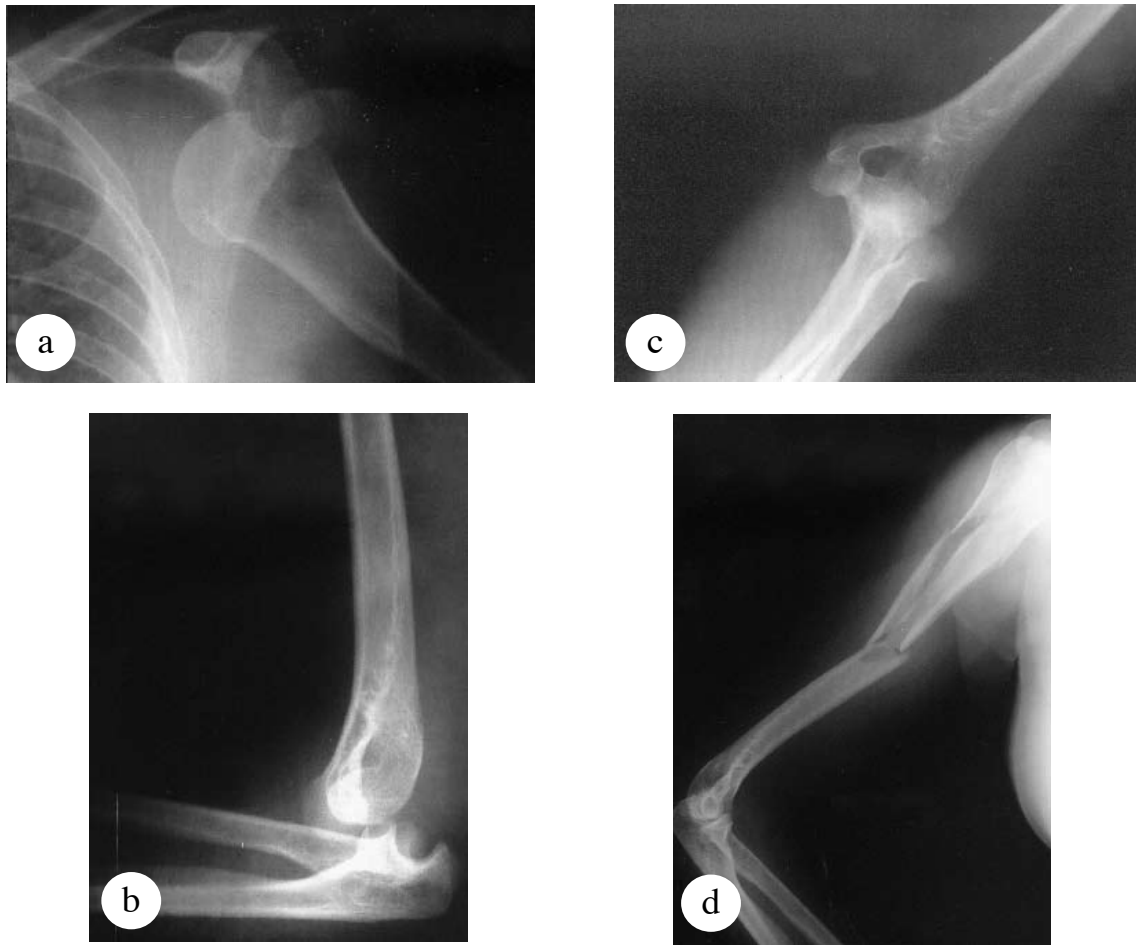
Initial x-rays of the left shoulder, elbow, and right humerus a) Anteroposterior dislocation and fracture of greater tuberosity in the left shoulder. b) Posterior dislocation of the left elbow in the lateral view. c) Anteroposterior view of the elbow. d) Comminuted fracture in the right humerus.
